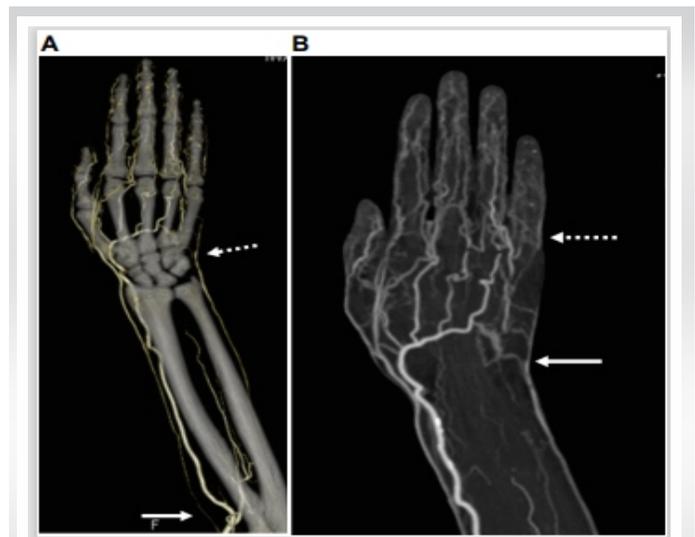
Contrast-enhanced CT findings after surgery. (a) 2 months after the surgery, contrast-enhanced CT showed blood vessels. The ulnar artery was nearly occluded at the bifurcation of the brachial artery (solid arrow), and the superficial palmar arch and palmar metacarpal artery were not visible (dashed arrow). (b) The palmar metacarpal artery was occluded (solid arrow). The radial side of the proper palmar digital artery from radial artery was enhanced (dashed arrow). The ulnar digital artery was also recanalized. CT: Computed tomography.
